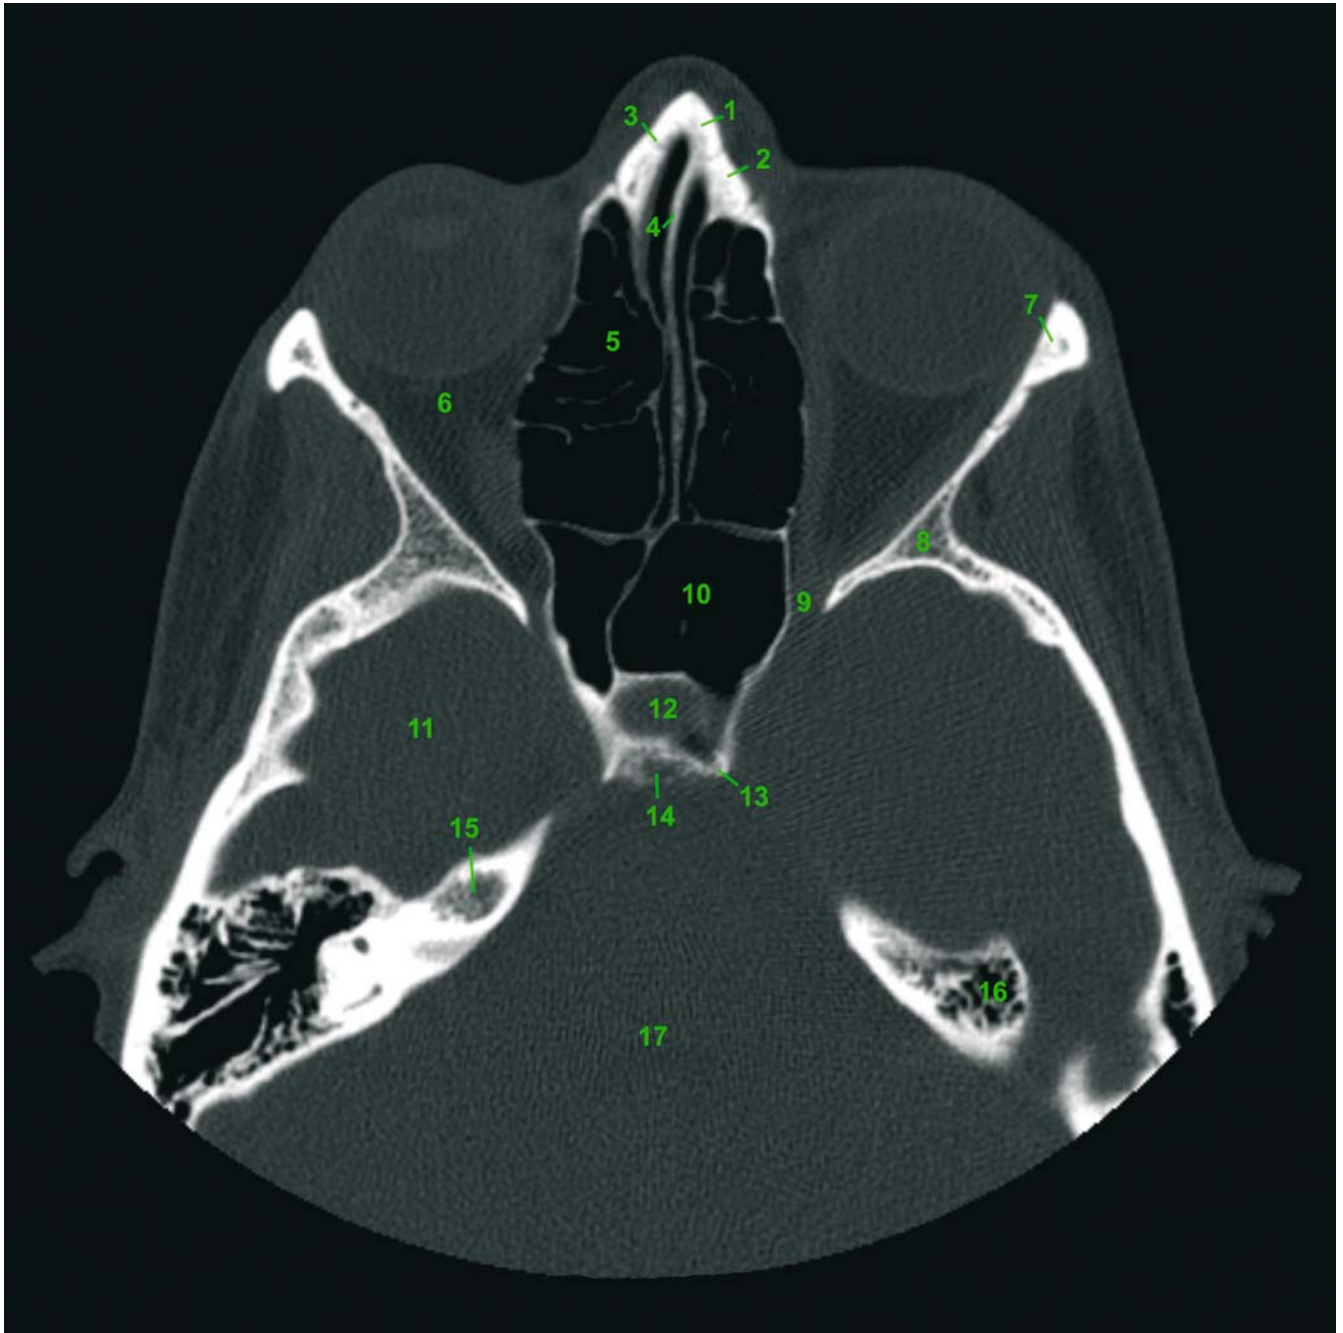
Axial CT slice 3 (patient K.C.). 1 Nasal bone; 2 Maxillary bone; 3 Nasomaxillary suture; 4 Nasal septum; 5 Ethmoid air cells; 6 Orbita; 7 Frontal bone; 8 Sphenoid bone; 9 Superior orbital fissure; 10 Sphenoidal sinus; 11 Medial cranial fossa; 12 Sella turcica; 13 Posterior clinoid process; 14 Dorsum sellae; 15 Internal acoustic meatus; 16 Mastoid air cells; 17 Posterior cranial fossa
